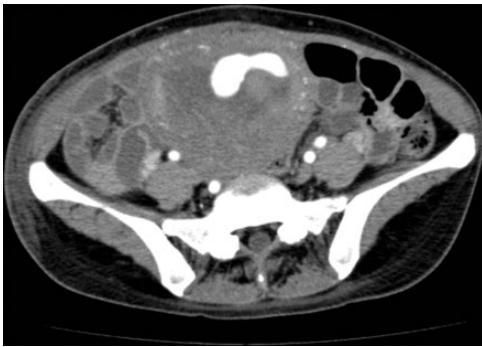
Computed tomography image of a ruptured uterine artery pseudoaneurysm. Contrast agent was extravasated toward the uterine cavity.
